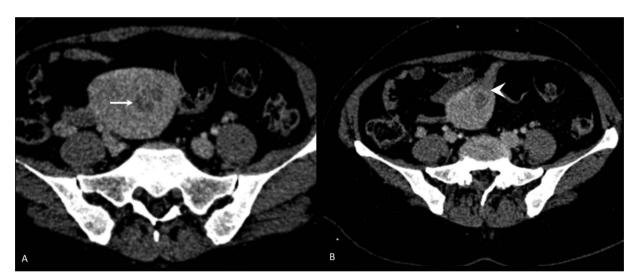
CECT abdomen in endometrial carcinoma. Patient had pacemaker and MRI was contraindicated. An ill-defined heterogeneously enhancing lesion in the endometrial cavity (arrow in A) with >50% invasion into myometrium (arrowhead in B).
